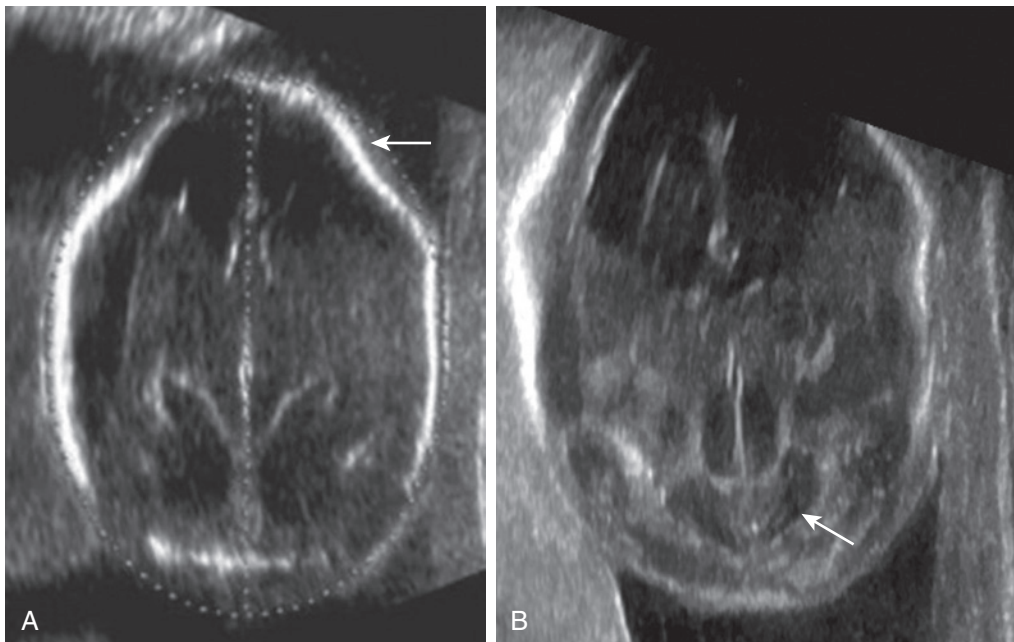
Fetal cranial ultrasound features associated with open neural tube defects. (A) The "lemon-shaped" cranium due to frontal bone scalloping (arrow). (B) The "banana sign" of the compressed cerebellum (arrow). (From Coady AM. *Twining's Textbook of Fetal Abnormalities*. Chapter 11, 223–263 Copyright © 2015, 2007, 2000 by Churchill Livingstone, an imprint of Elsevier Limited. All rights reserved.)
